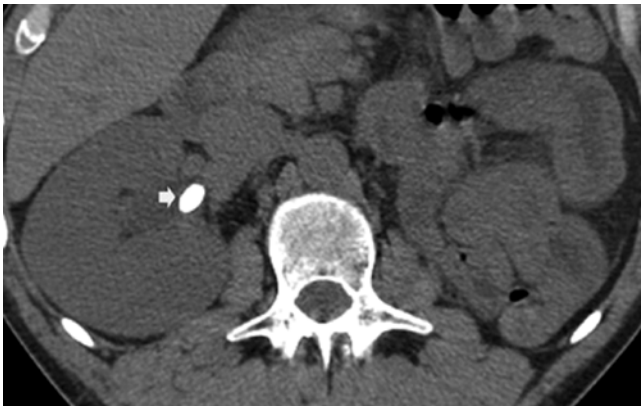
Unenhanced CT scan demonstrating a right renal pelvis calculus (*arrow*) in a patient with solitary kidney
